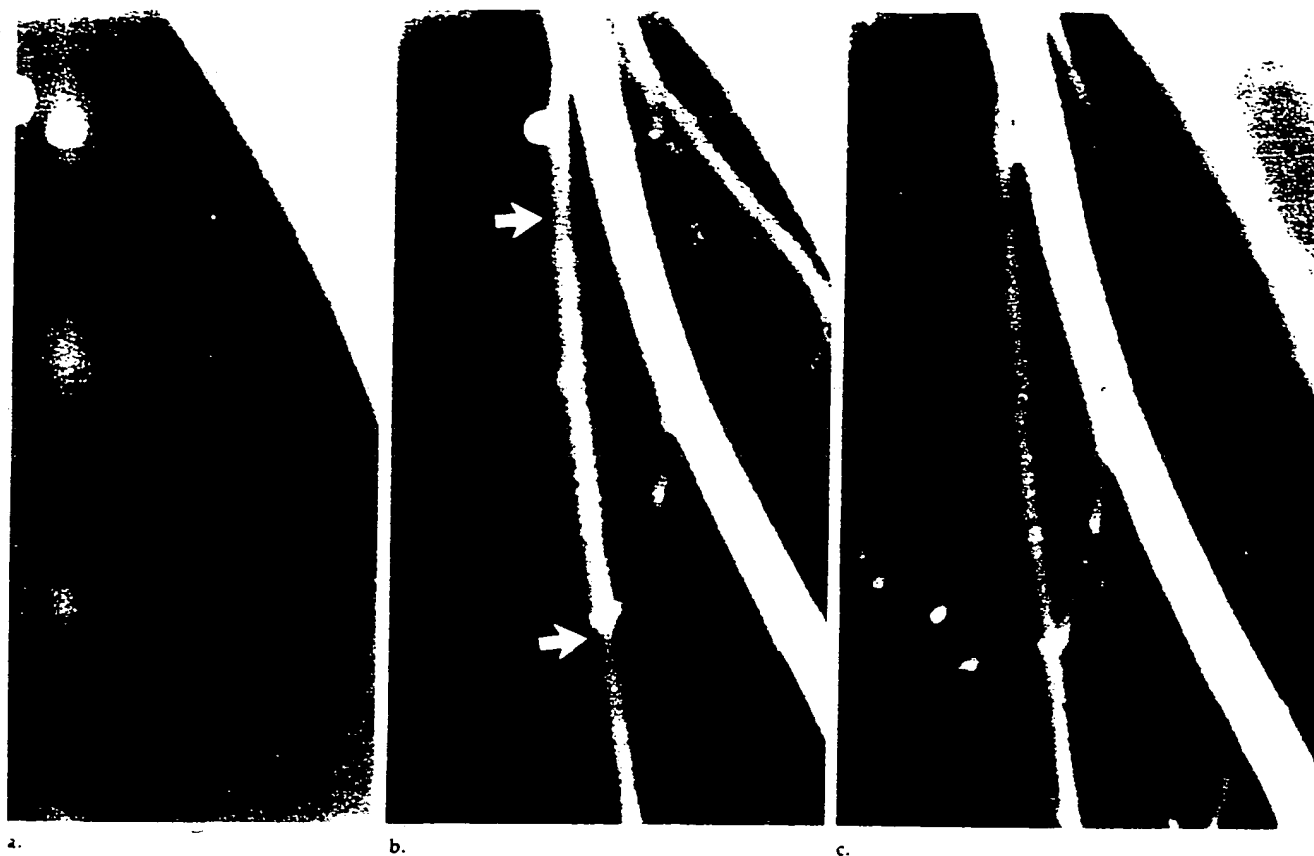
Collimated views of conventional radiograph (a) and superficial femoral arteriogram (b) obtained immediately after stent insertion in the left saphenous artery. The stent is fully expanded, and the vessel lumen is patent. Note dilatation of the artery at the site of balloon inflation (arrows, b). (c) Arteriogram obtained 6 weeks after insertion demonstrates a 25% luminal narrowing within the stent. The stent diameter is unchanged, and there is slight luminal narrowing at the origin of one small side branch.
